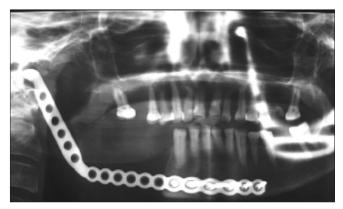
(c): Postoperative radiograph (orthopantomogram) showing resected right mandible and titanium reconstruction plate with good positioning of prosthetic condyle in glenoid fossa.
